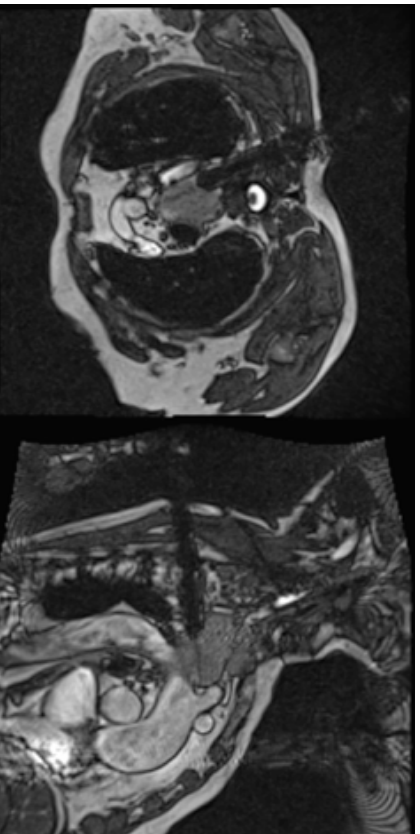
biopsy of a mediastinal mass using a posterior approach. MRI clearly shows the mass, the lung and the great vessels.
